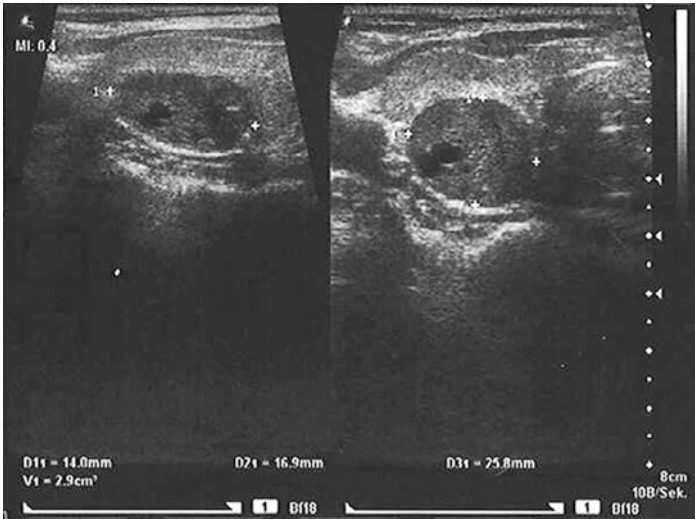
Ultrasound of hyperplastic parathyroid remnant 13 years after subtotal parathyroidectomy. (With kind approval of Dr. M. Tosch, head of department of nuclear medicine, Helios university hospital, Wuppertal)
